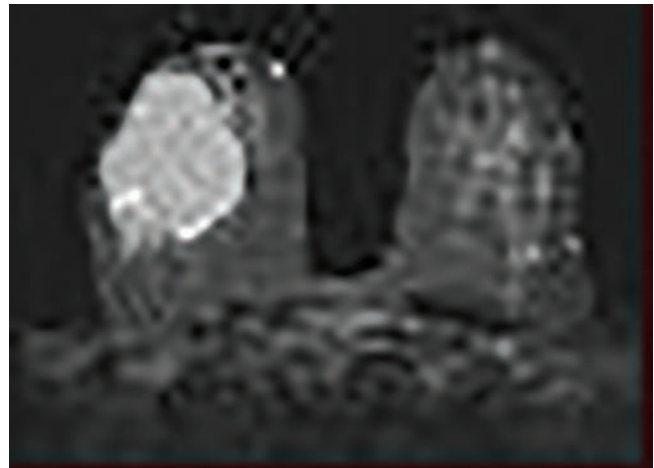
Patient's 2024 MRI image.
